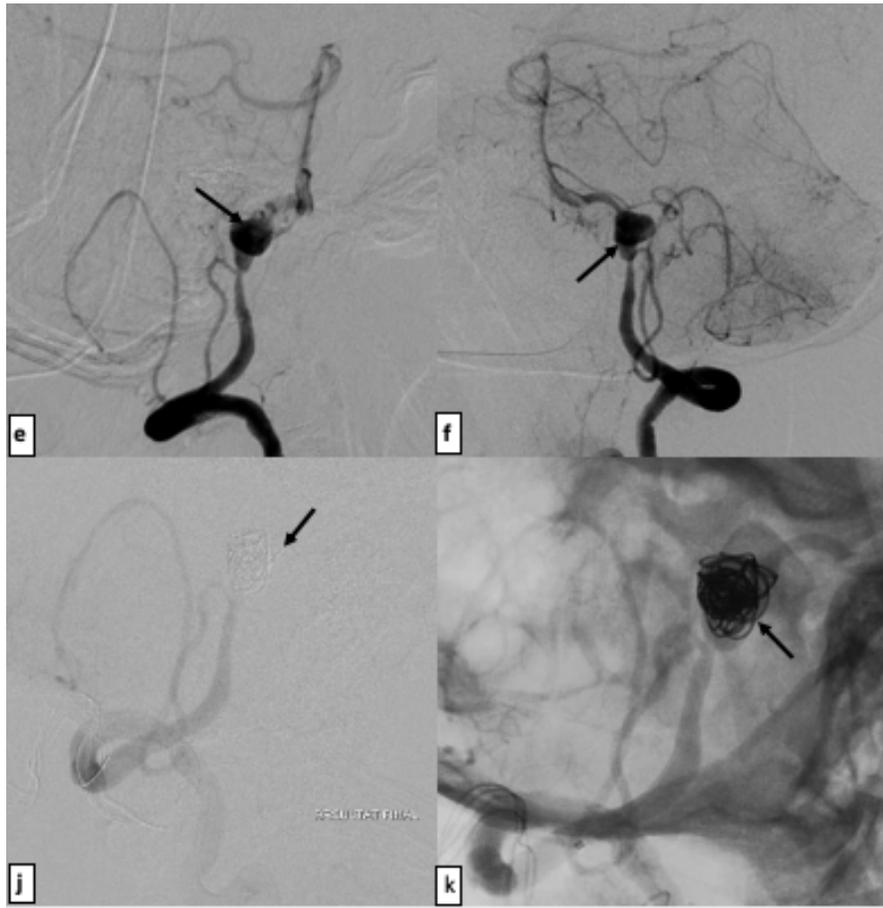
45 years old patient with a loss of consciousness. (a, b): Axial non enhanced brain CT: peri mesencephalic and bilateral sylvien fissures subarachnoid hemorrhage and hydrocephalus. (c, d): Brain CT angiography in arterial phase in axial section (b) and sagittal section (c): narrowing of the left vertebral artery after the emergence of Posterior Inferior Cerebellar Artery (PICA) with individualization of a dissecting aneurysm. (e, f, j, k): Brain arteriography confirms the presence of a dissection of the vertebral artery, prior to the birth of PICA, complicated by a dissecting aneurysm. (f, j): Endovascular treatment in the same patient: embolization of the artery carrying the aneurysm by coils with extinction of the aneurysm and preserving the PICA.
